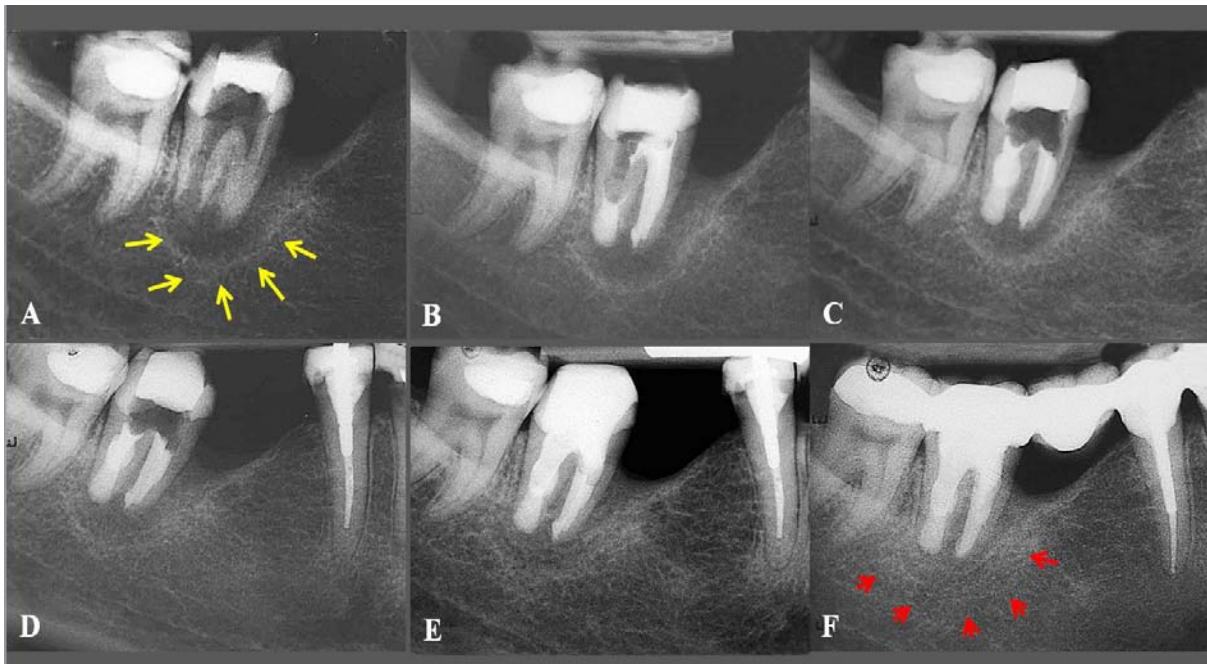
A/Initial radiographic situation - PAI5; B/Post-operative radiograph of obturation of medial canals and apical zone of distal canal with MTA; C/Post-operative radiograph after 3 months; D/Post-operative radiograph after 6 months; E/ Post-operative radiograph after 12 months; F/ Post-operative radiograph after 2 years - the definitive prosthetic restoration was done an year ago
